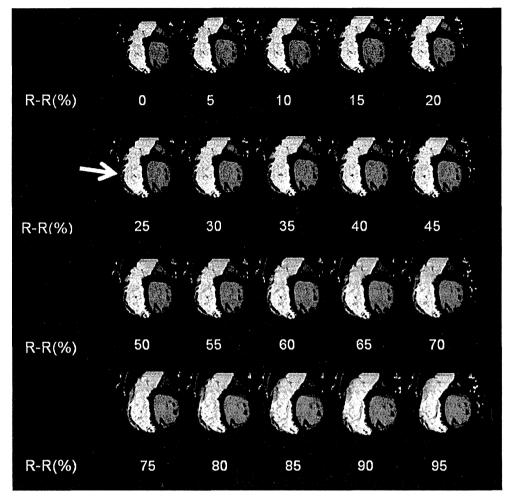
Typical images of right ventricular (RV) wall motion asynergy on four dimensional computed tomography (CT) analysis. Multiplanar reconstruction images of short axis of left ventricle were reconstructed every 5% from 0 to 95% of the R–R interval (total, 20 phases). In this subject, impaired wall motion was observed mainly in a mid level of RV free wall (arrow).
